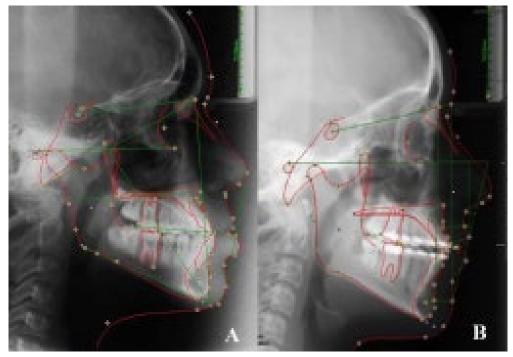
Lateral cephalometric radiographs of Non-surgery patient (a) pre-treatment (b) post-treatment.
